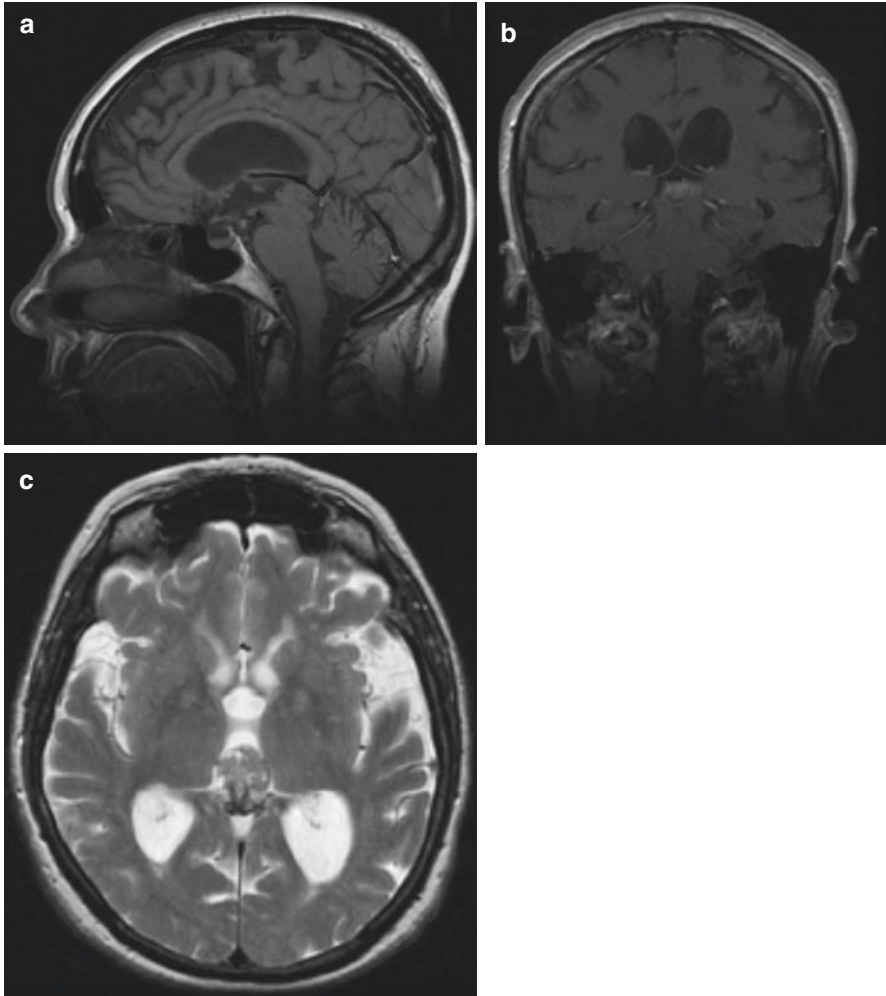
Pineocytoma in TIWI (a), T1WI with contrast (b), and T2WI (c) MRI sequences
